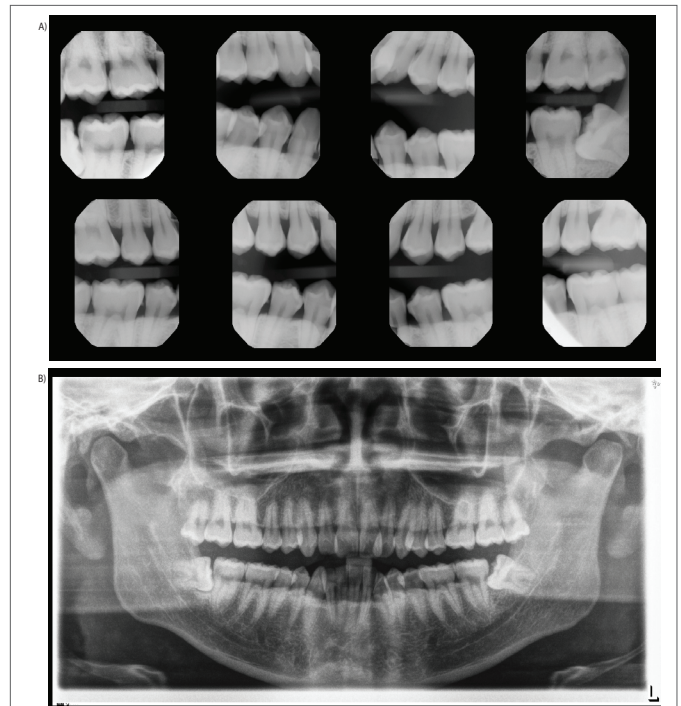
Initial vertical bitewings (A) and Pan (B) taken in an outside private practice prior to starting treatment at UMSoD.
